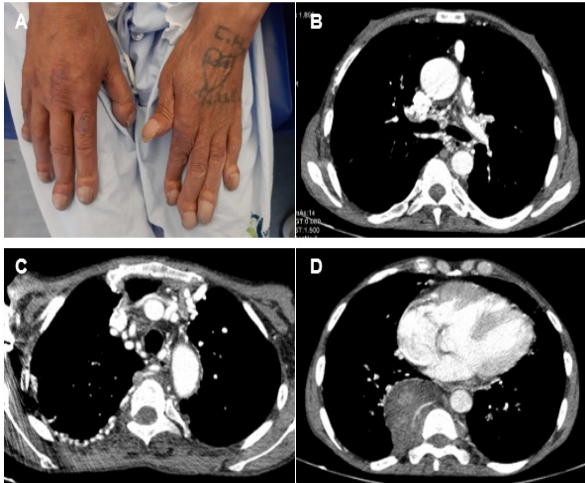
(A): Digital clubbing. (B,C): Chest CT confirmed the presence of a complex vascular malformation with a small pulmonary artery diameter and exuberant collateral circulation in the subpleural region of the RUL and left lung fissure. (D) Right paravertebral mass and some left paravertebral nodules, suggesting extramedullary hematopoiesis.
